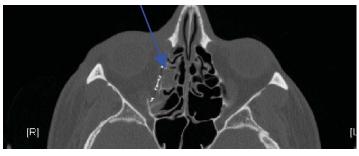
Coronal and axial views of computed tomogram (Case 7) demonstrating TITAN placement in medial wall and orbital floor fracture repair (arrows).
